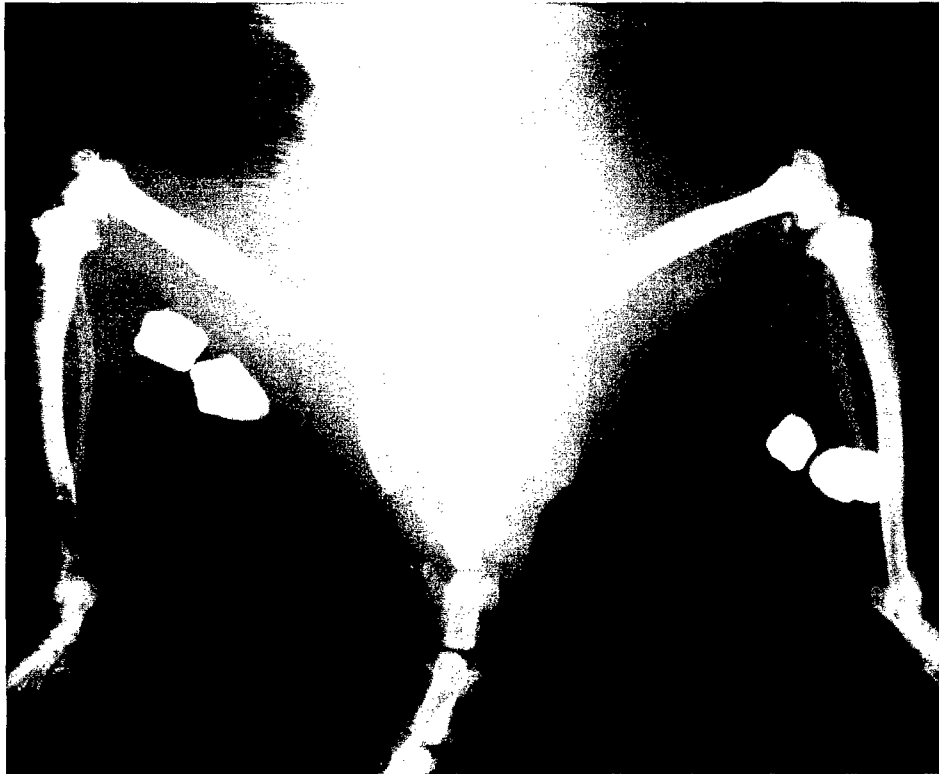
Radiograph of 5.0 x 5.0 x 1.5 mm DU(Ti) fragments 1 year after implantation.
